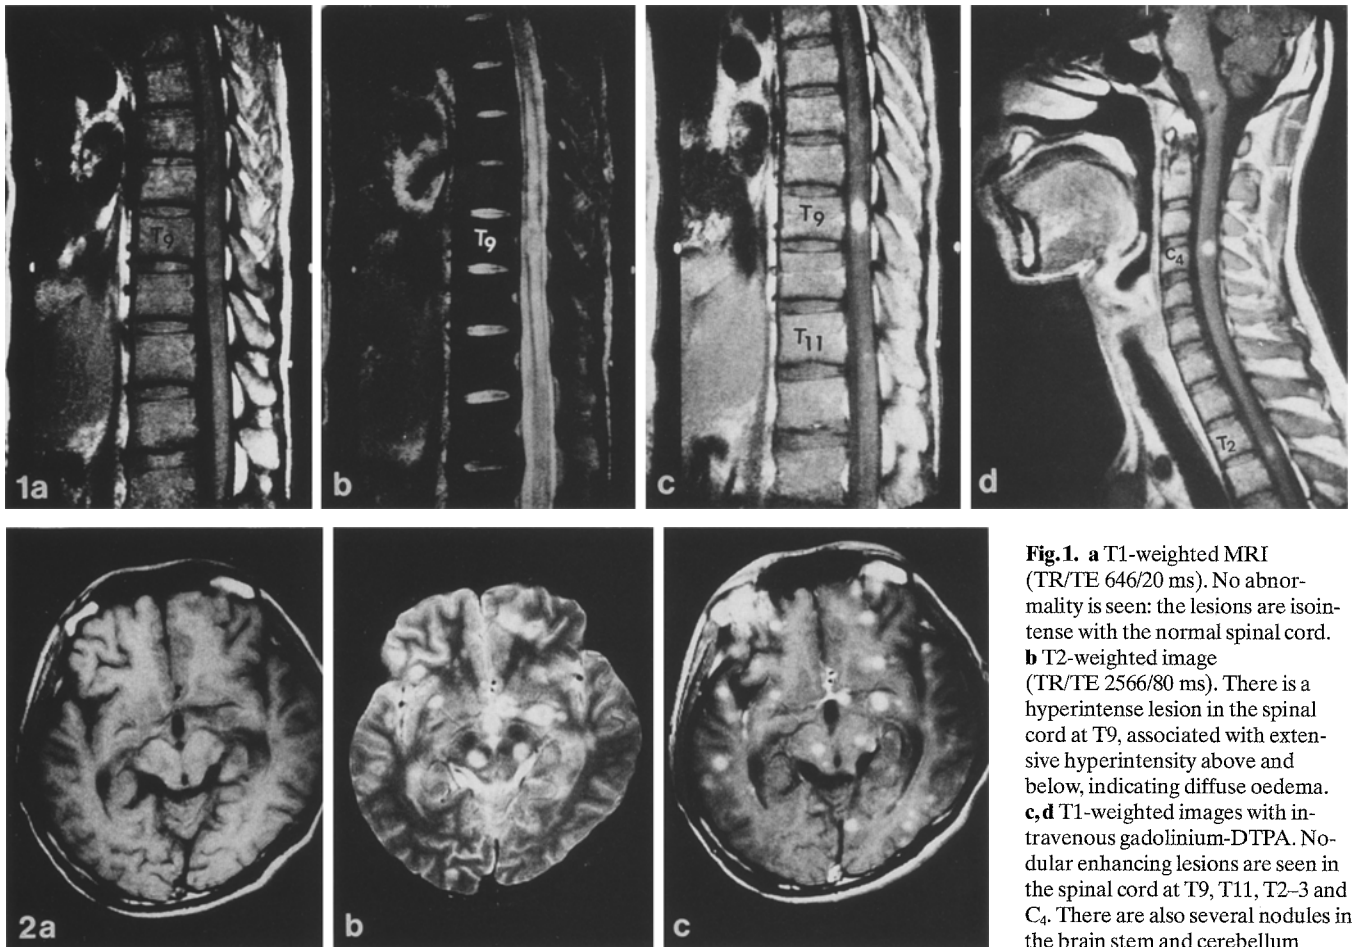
a T1-weighted MRI (TR/TE 646/20 ms). No abnormality is seen: the lesions are isointense with the normal spinal cord. b T2-weighted image (TR/TE 2566/80 ms). There is a hyperintense lesion in the spinal cord at T9, associated with extensive hyperintensity above and below, indicating diffuse oedema. c, d T1-weighted images with intravenous gadolinium-DTPA. Nodular enhancing lesions are seen in the spinal cord at T9, T11, T2-3 and C4. There are also several nodules in the brain stem and cerebellum
